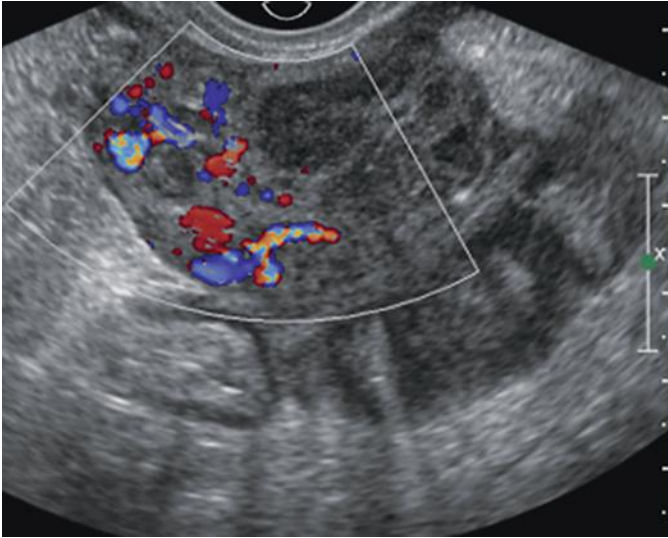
Diverticular abscess. Complex, hypervascular left adnexal mass adjacent to thick-walled bowel loop in a 62-year-old woman who presented with left-sided pelvic pain and fever. At surgery this mass was found to be a diverticular abscess. Diverticular abscess is more likely to occur in older women, be unilateral and left-sided, contain air, and be associated with abnormal loops of bowel. (From Baltarowich OH, Scoutt LM, Hamper UM: Nongynecologic findings on pelvic ultrasound: focus on gastrointestinal diseases. *Ultrasound Q* 28:65-85, 2012, used with permission.)
